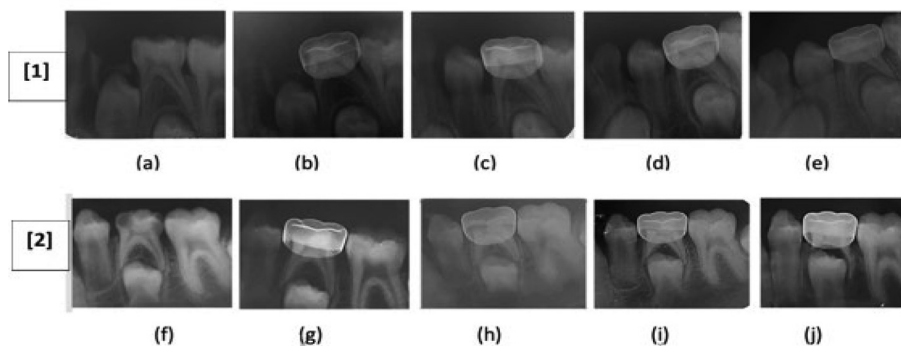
[1]: Radiographic follow up for a lower 2nd primary molar treated with SDF + hall technique, (a) Pre-operative radiograph, (b) immediate post-operative radiograph, (c) 3 months follow up, (d) 6 months follow up, (e) 1 year follow up, and [2]: radiographic follow-up for a child with lower 2nd primary molar treated with laser + hall technique, (f) pre-operative radiograph, (g) immediate post-operative, (h) 3 months follow up, (i) 6 months follow up, (j) 1 year follow up.
